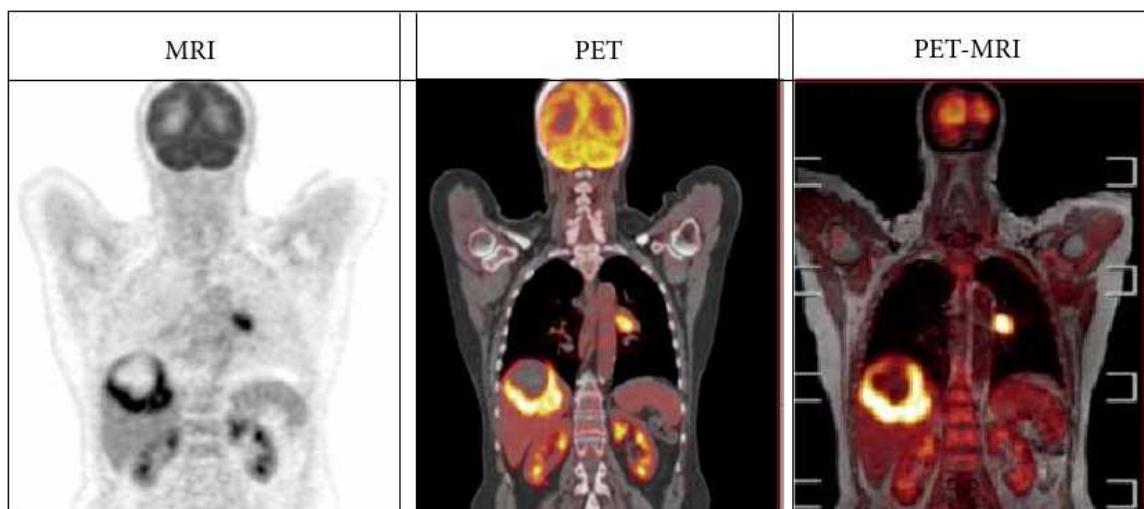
Representative clinical whole-body PET (left), PET/CT (middle) and PET/MR (right) images of the same patient acquired sequentially (~70 min time difference) on two combined systems (Siemens Biograph Hirez TrueV and Philips Ingenuity TF PET/MRI, respectively) following injection of 370 MBq of ¹⁸F-FDG. Courtesy of Geneva University Hospital.
